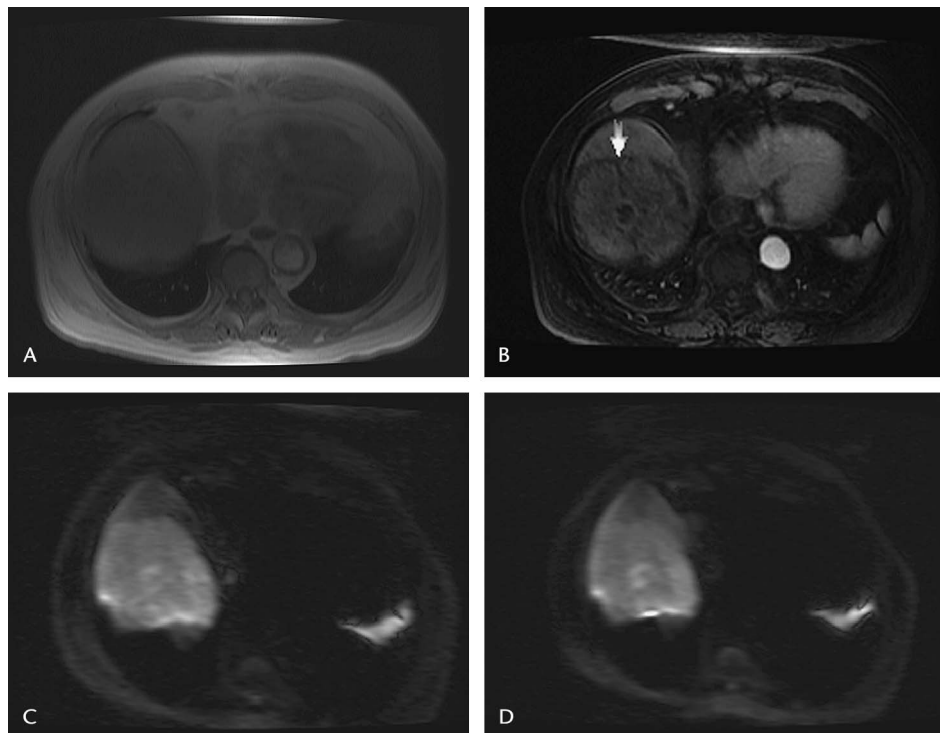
Images in a 75-year-old man with hepatocellular carcinoma (arrow). Precontrast T1-weighted spin echo image (A), postcontrast T1-weighted gradient echo image (B), precontrast apparent diffusion coefficient (ADC) map (C), and postcontrast enhanced ADC map (D) are shown. The overall appearance of the liver and lesion conspicuity are not significantly different between the precontrast and postcontrast ADC maps.
